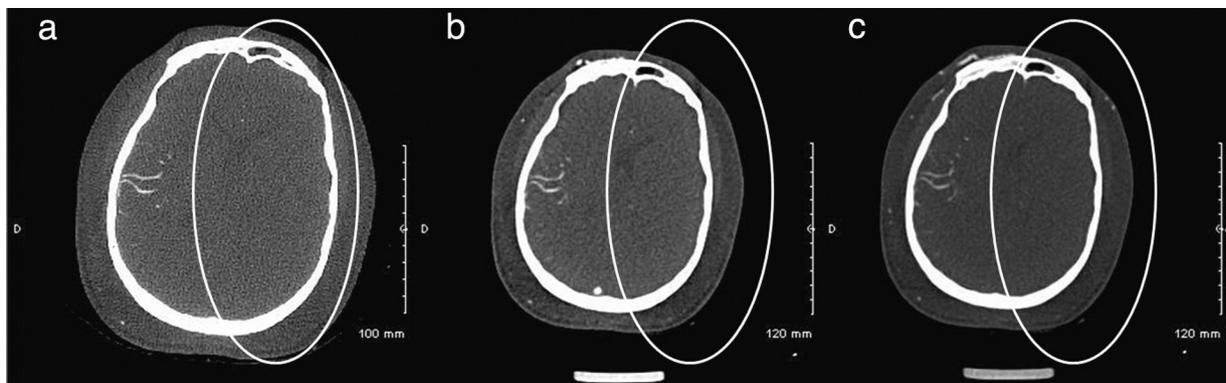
Axial reconstructions of the cerebral vascular supply after multi-phase post-mortem CT angiography, (a) after arterial injection, (b) after venous injection, (c) after dynamic injection. Absence of opacification of the left middle cerebral artery during the three different times of acquisition (circle).
